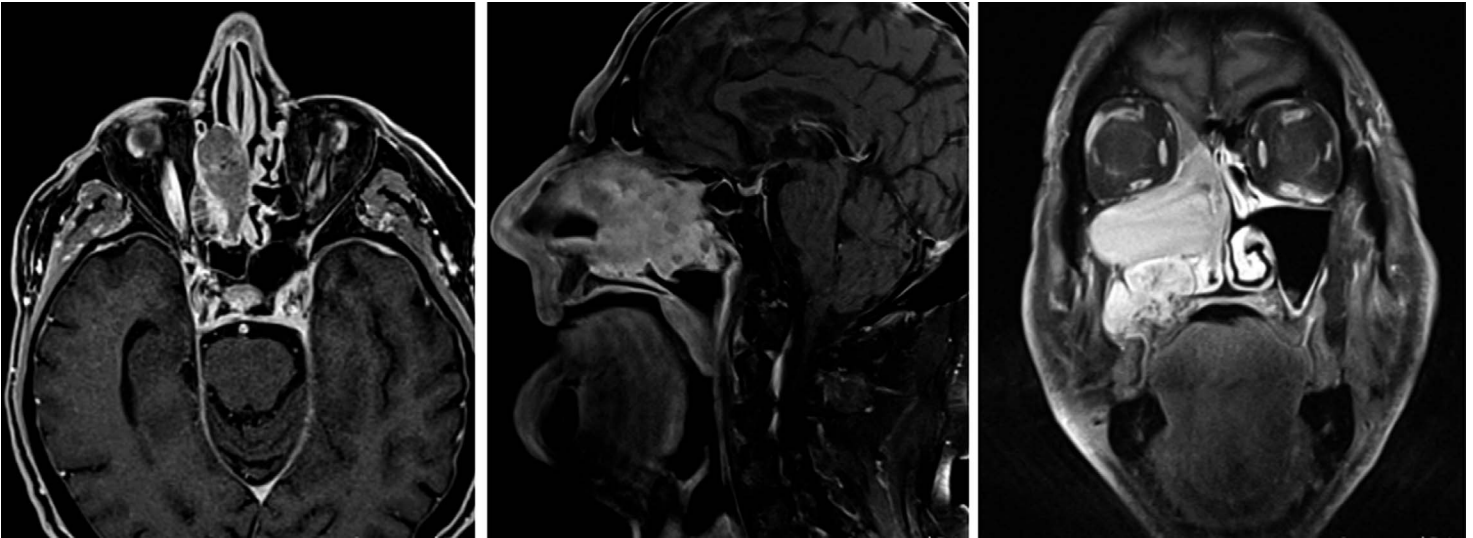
Axial, sagittal, and coronal contrast-enhanced magnetic resonance images showing ameloblastoma extension on May 2013.
